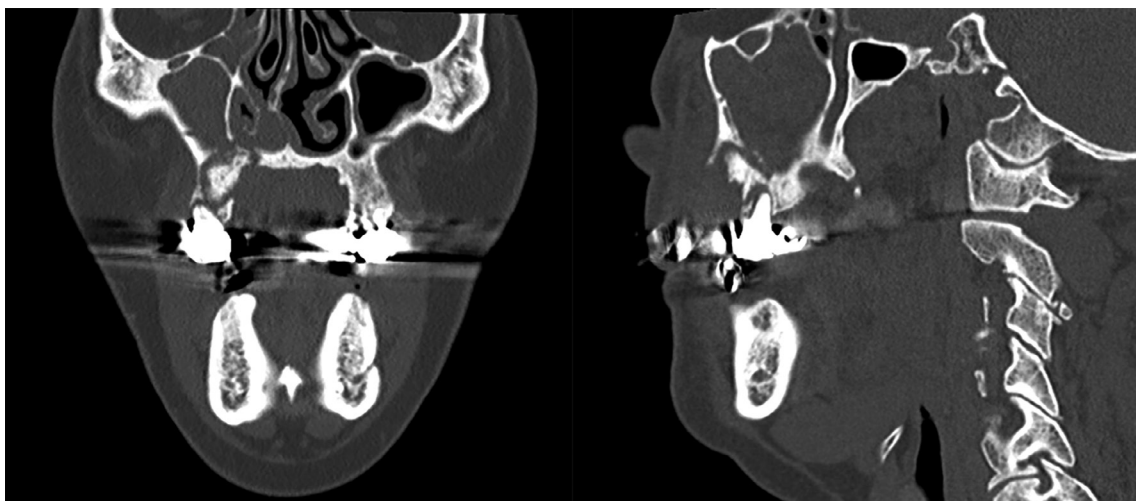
A 67-year-old male was diagnosed with Stage 1 MRONJ after the upper right first premolar extraction. He had a history of prostate cancer and prolonged use of zoledronate for five years and was during chemotherapy. The coronal and sagittal CT display a cortical sequestrum at the right maxilla with oronasal communication, and complete obliteration of the right maxillary sinus with high-density fluid is also observed. MRONJ, medication-related osteonecrosis of the jaw.
